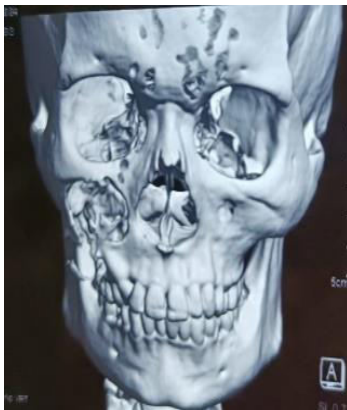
Computed tomographic images showing high-density cystic lesion without contrast enhancement. The thinned anterior wall of the maxillary sinus and zygomatic buttress resulted from bony remodelling
